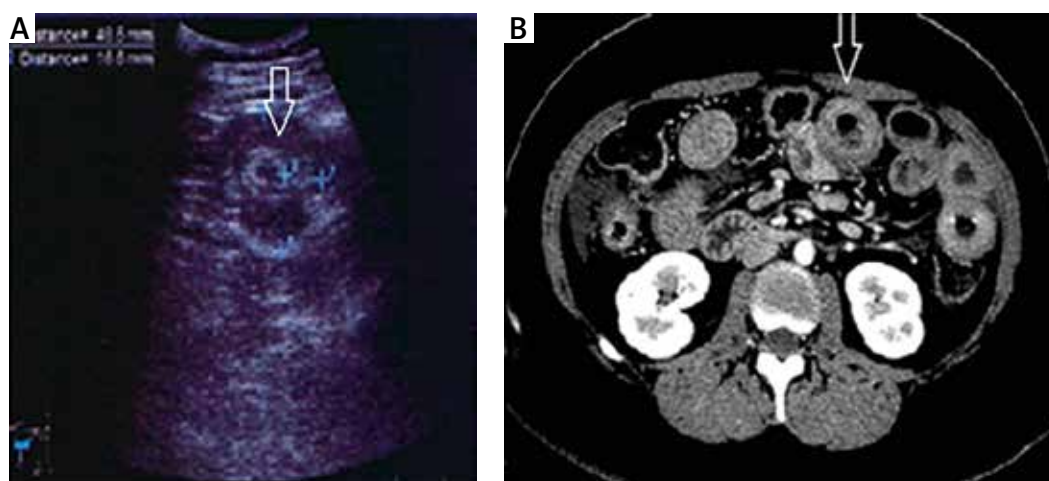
Abdominal and pelvic ultrasound and computed tomography finding during acute abdominal attack in the course of hereditary angioedema
